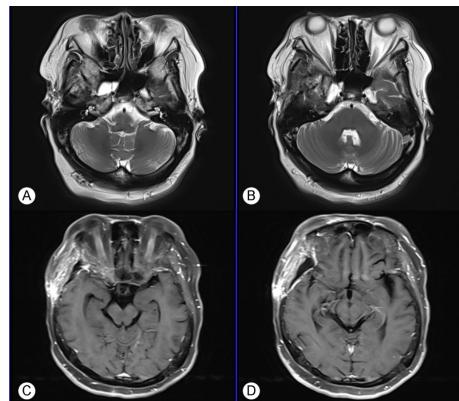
The postoperative MRI of Case 1. (A)~(D): The signal of cerebrospinal fluid in the sphenoid sinus and meningeal brain protrusion at the leakage site disappeared. The signal of fluid in the Sternberg's Canal decreased significantly, and the anterior clinoid meningioma was completely resected
